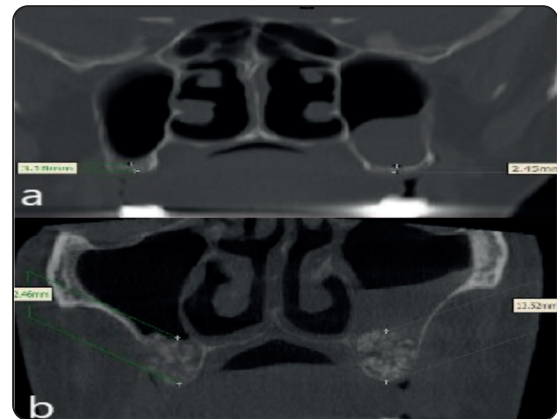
Coronal cut of CBCT showing residual ridge height assessment: a) Preoperative, b) Postoperative following grafting.
